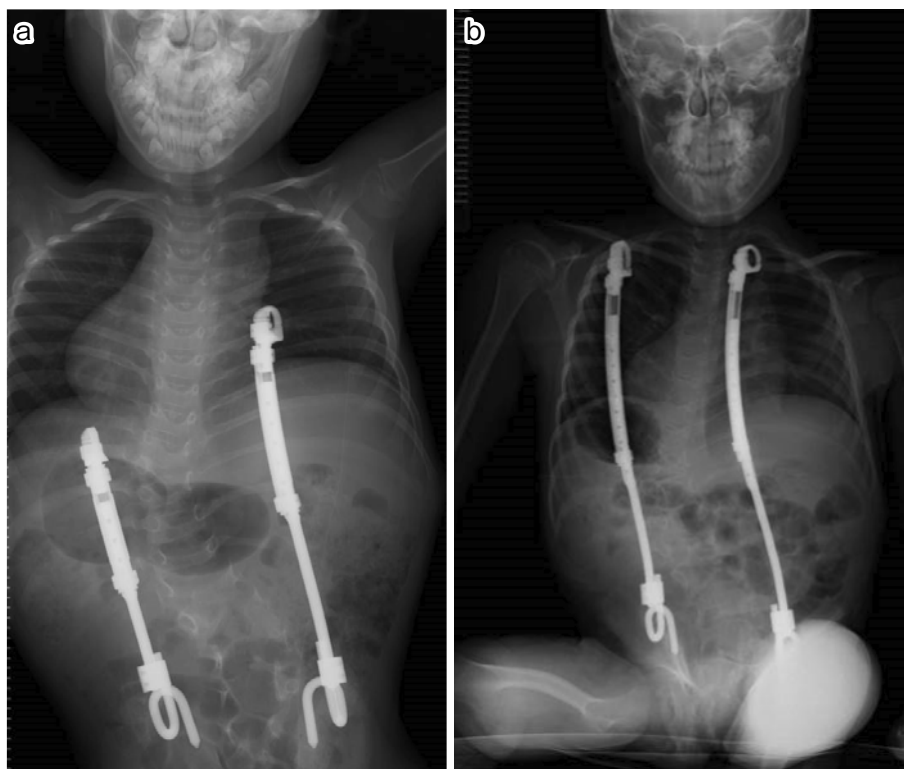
Postoperative plain X-ray images of growth-friendly surgery using VEPTR. a: after index surgery; b: after the fifth extension following replacement.
